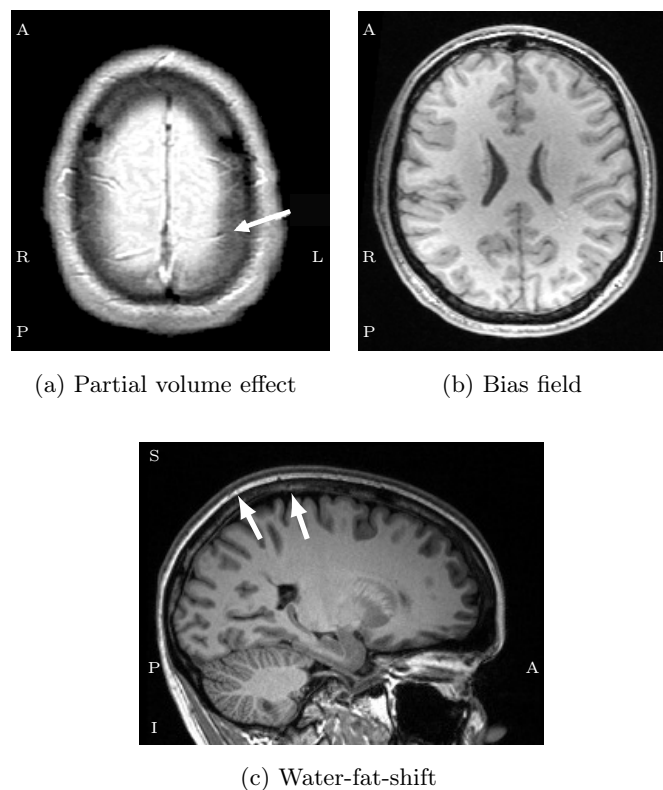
Slices of MR images displaying some of the most relevant artifacts.
